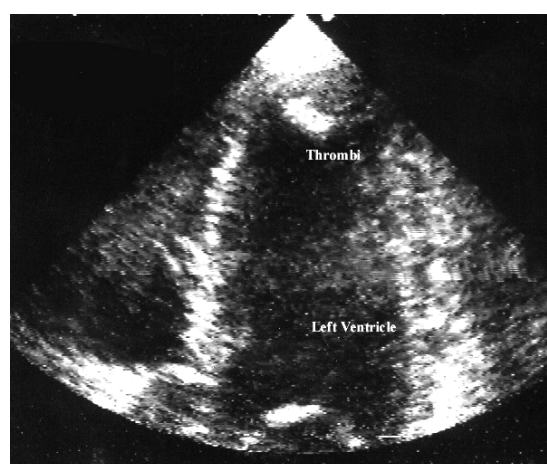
Left ventricle postinfarction aneurism. Transthoracic EchoCG. Apical two-chamber view. At the LV apex hyperechogenic thrombotic masses are located.
